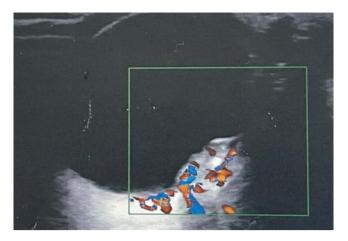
Vascular flow on Doppler ultrasound of the left eye.
